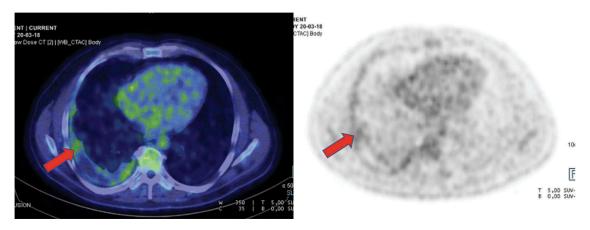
FDG-PET shows an increased uptake in the right-sided pleural effusion.
